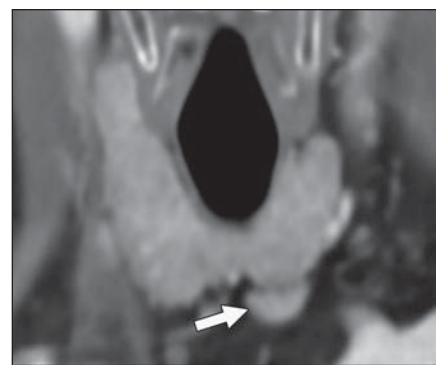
65-year-old woman who underwent contrast-enhanced neck CT owing to recently diagnosed oral tongue squamous cell carcinoma. Coronal image shows avidly enhancing nodule (arrow) along inferior aspect of left thyroid lobe. Interpreting neuroradiologist suspected this finding to represent opportunistically identified enlarged left inferior parathyroid gland and included in clinical report recommendation for biochemical evaluation for possible primary hyperparathyroidism. Recommended laboratory testing was performed and yielded results consistent with primary hyperparathyroidism. Subsequently, lesion was surgically resected and confirmed to represent hypercellular parathyroid gland.
